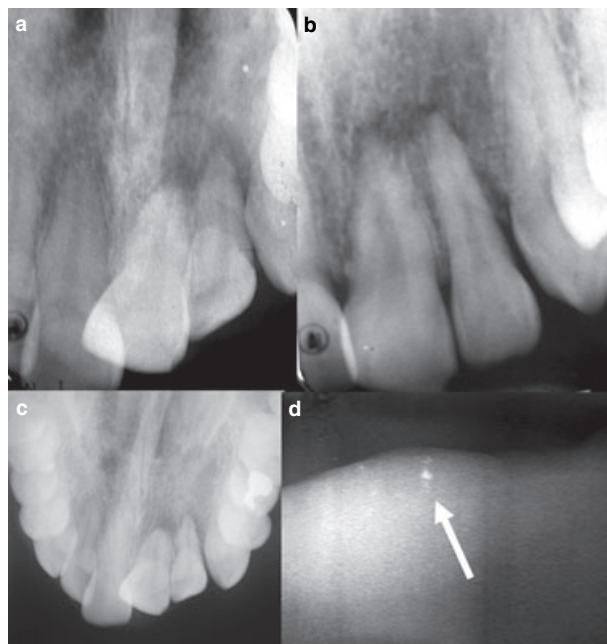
(a, b) Periapical radiographs demonstrating periradicular radiolucencies associated with the traumatic displacement of the maxillary left incisors. (c) Occlusal radiograph of the pre-maxilla. (d) A radiopaque particle consistent with a tooth fragment is apparent on the soft tissue radiograph of the lower lip.
